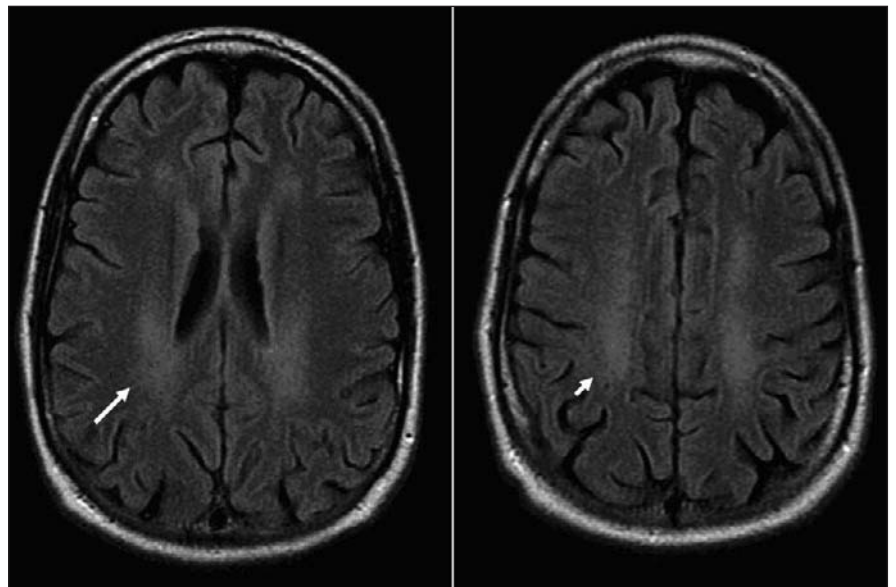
Magnetic resonance imaging scans of the brain, showing changes consistent with cobalamin deficiency. Fluid-attenuated inversion recovery (FLAIR) images show diffuse hyperintense signal changes in the periventricular (long arrow) and deep subcortical white matter (short arrow) involving both cerebral hemispheres. Moderate atrophy is demonstrated by sulcal widening to an extent not in keeping with the patient's age.
